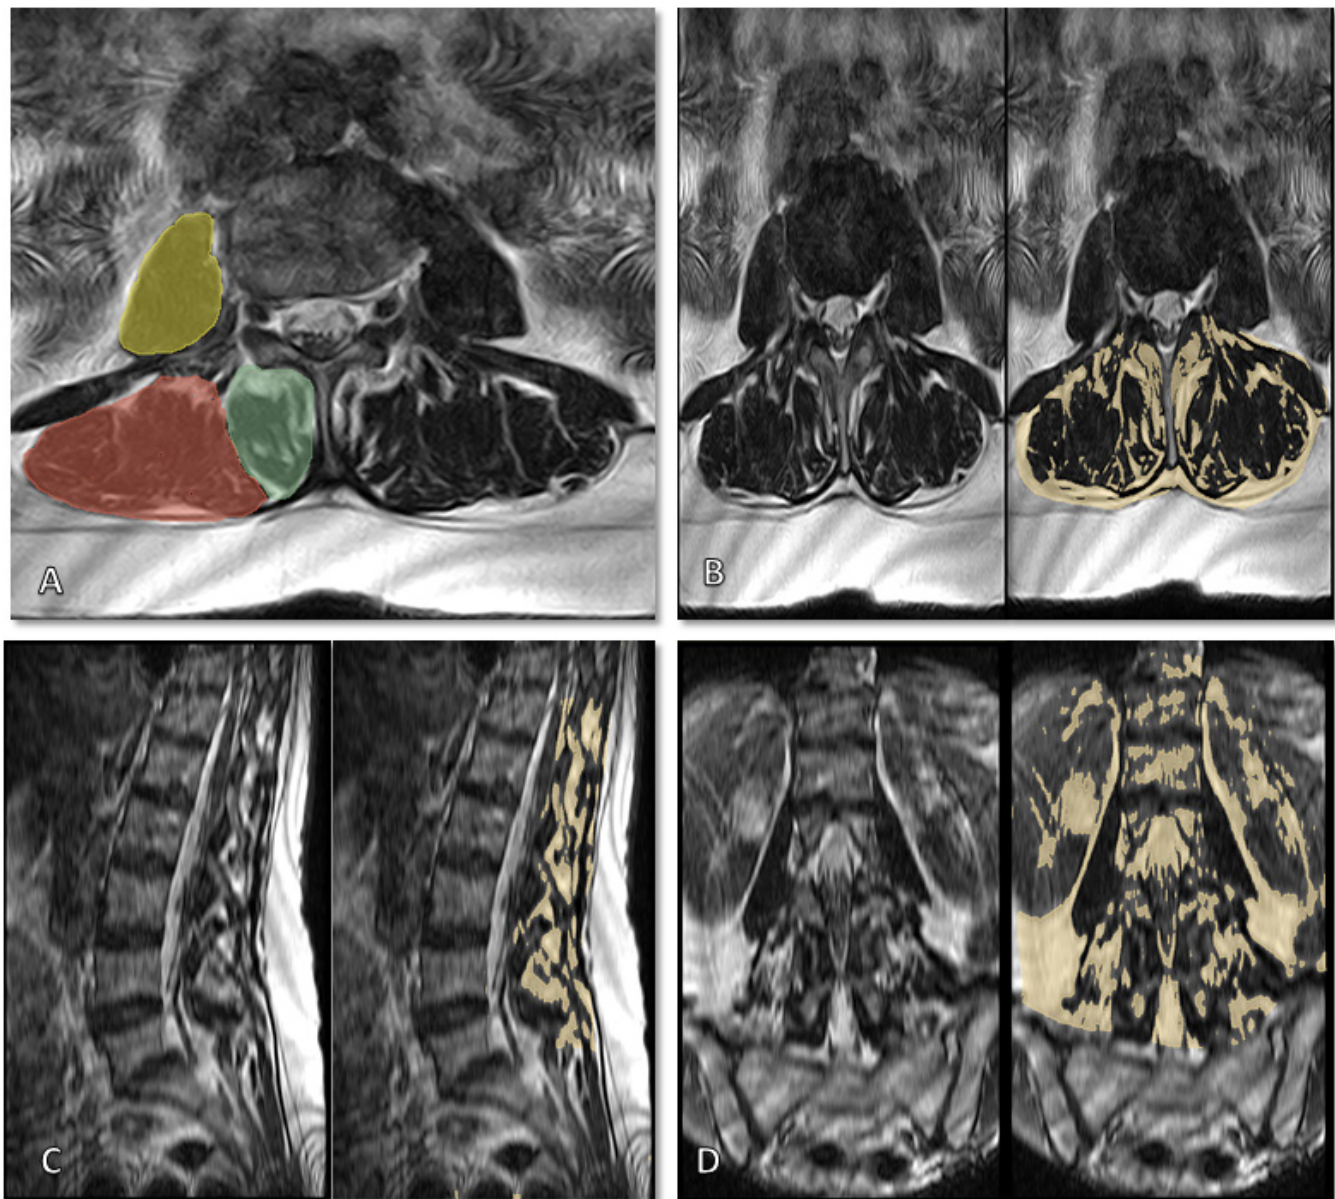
(A) Example of paraspinal muscle cross-sectional area segmentation at L4 to L5 level. The multifidus muscle segmentation is in green, the erector spinae in red, and the psoas major in yellow. (B) Axial T2-weighted scan. (C) Sagittal T2-weighted scan. (D) Coronal T2-weighted scan. MRI scan of the whole lumbar segment. On the left of each image is the MRI. On the right, semiquantitative contouring of fatty infiltration for 3-dimensional model building.
